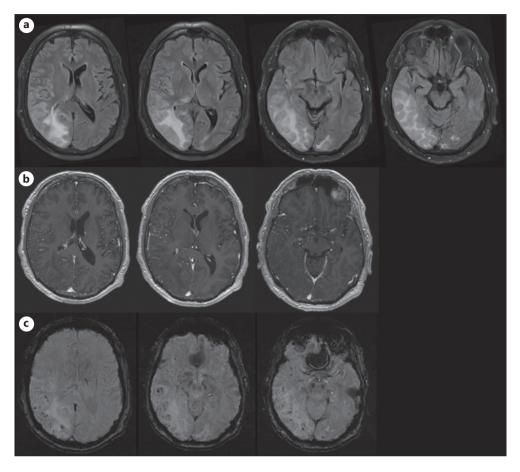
Repeated MRI (on day 12, 5 November 2019) showing an increase in the right parieto-temporo-occipital hyperintensities, extending to the right thalamus (FLAIR with hyperintensities (a); T1 with gadolinium injection showing no enhancement (b); susceptibility weighted imaging showing multiple microbleeds (c)).
